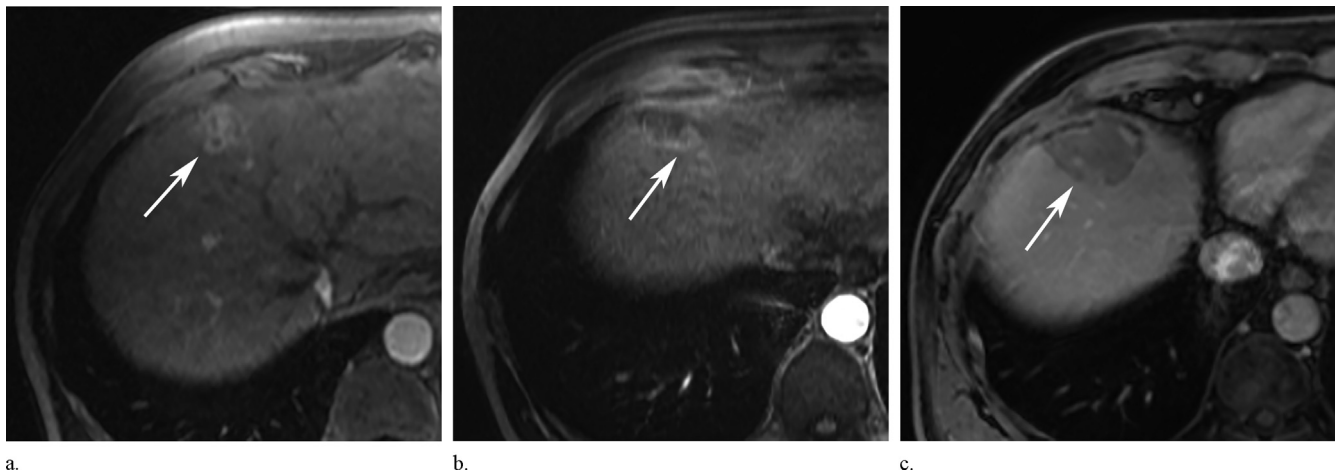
Hypervascular HCC in a 61-year-old man with chronic hepatitis C. (a) Gadolinium-enhanced T1-weighted magnetic resonance image shows a 2.7-cm nodule at hepatic dome (arrow). (b) Image obtained 8 months after MWA shows LTP at posterior edge of ablated zone (arrow). (c) Gadolinium-enhanced T1-weighted MR image shows new ablation zone completely encompassing the target tumor (arrow).
